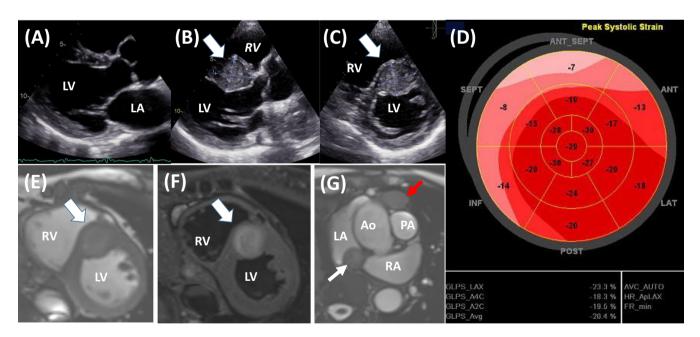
A, Baseline echocardiography, parasternal long axis, showing no tumour. B and C, Echocardiography, parasternal long and short axis, showing IVS tumor marked with white arrow. D, Global longitudinal strain, Bulls Eye representation, showing regional impaired strain values due to IVS Tumor. E, CMR Short axis T2 weighted sequence of the IVS tumor marked with white arrow. F, CMR Short axis T2 weighted sequence with fat-supression (STIR) of the IVS tumor marked with white arrow. G, CMR Short axis T2 weighted sequence showing additional lesions in the pericardium, ventral to the ascending aorta (red arrow), and in the interatrial septum towards the right atrium (white arrow)
